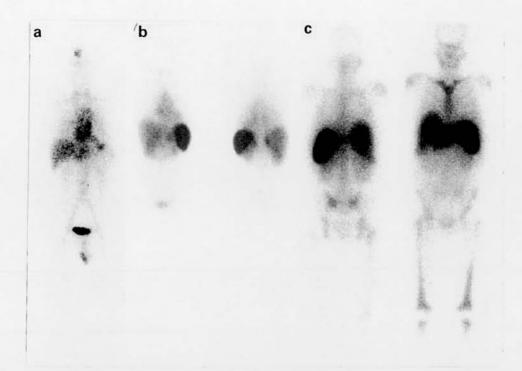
Whole body scintigraphs 24 h after intravenous injection of ¹²³I-labelled human SAP. a, anterior view of normal control subject showing distribution of residual tracer in the blood pool and radioactive breakdown products in urine in the bladder; note the absence of localisation or retention of tracer anywhere in the body. b, anterior (left) and posterior (right) views of patient with juvenile chronic arthritis complicated by AA amyloidosis. There is uptake of tracer in the spleen, kidneys and adrenal glands, a typical distribution of AA amyloid in which the spleen is involved in 100% of cases, kidneys in 75% and adrenals in 40%. c, posterior (left) and anterior (right) views of patient with monoclonal gammopathy complicated by extensive AL amyloidosis. There is uptake and retention of tracer in the liver, spleen, kidneys, bone marrow and soft tissues around the shoulder. Note the complete absence of blood pool or bladder signal compared to a. This pattern of amyloid distribution revealed by scintigraphy is pathognomonic for AL amyloidosis, bone marrow uptake never having been seen in any other type.
